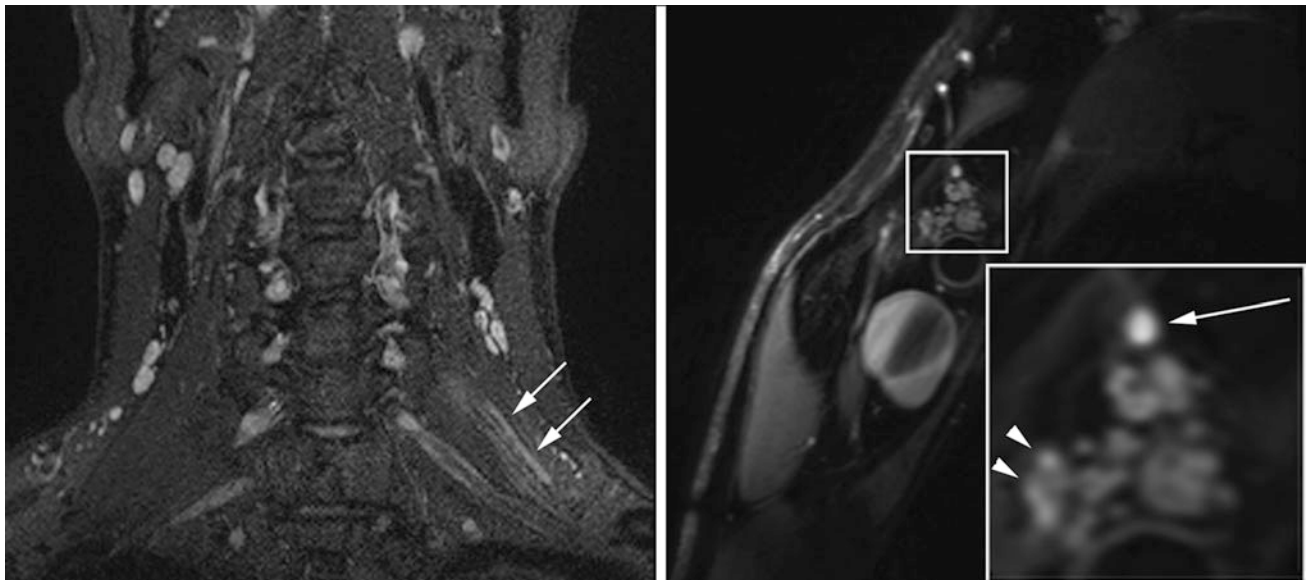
Patient with inflammatory left radiculopathy of C5. Coronal SPACE (Sampling Perfection with Application optimized Contrasts using different flip angle Evolution) with fat-saturation by inversion-recovery reveals markedly hyperintense C5 spinal nerve (*arrows*). The sagittal-oblique T2-weighted fat-saturated image with high resolution
